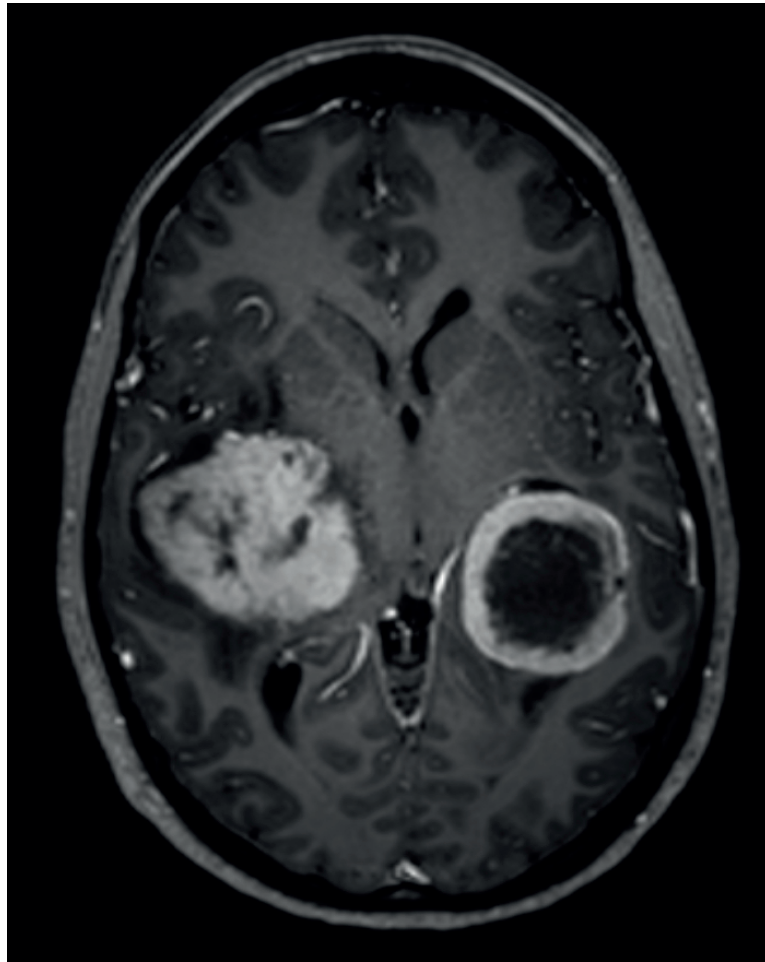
MRI T1 with gadolinium axial showing a right lenticular lesion measuring 49×47×44 mm and a left retrolenticular lesion measuring 38×37×36 mm with heterogenous contrast enhancement and a necrotic core.
